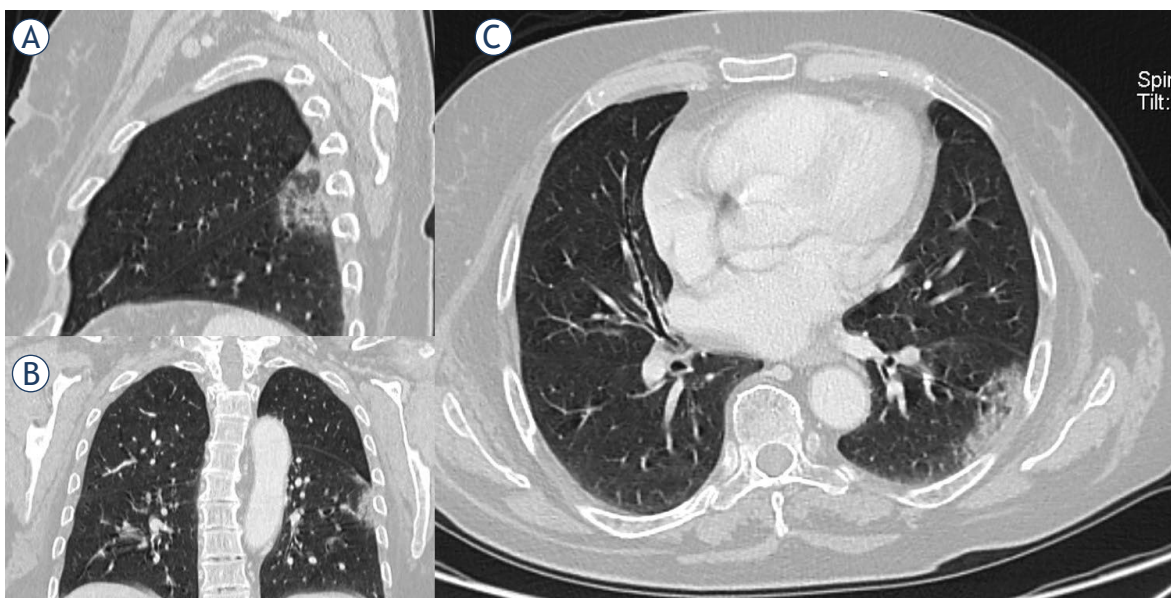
Woman, 54 year. CT shows patchy consolidation in apical segment of left lower lung. (A) Multiplanar reconstruction in sagittal plane; (B) multiplanar reconstruction in coronal plane; (C) axial plane.
